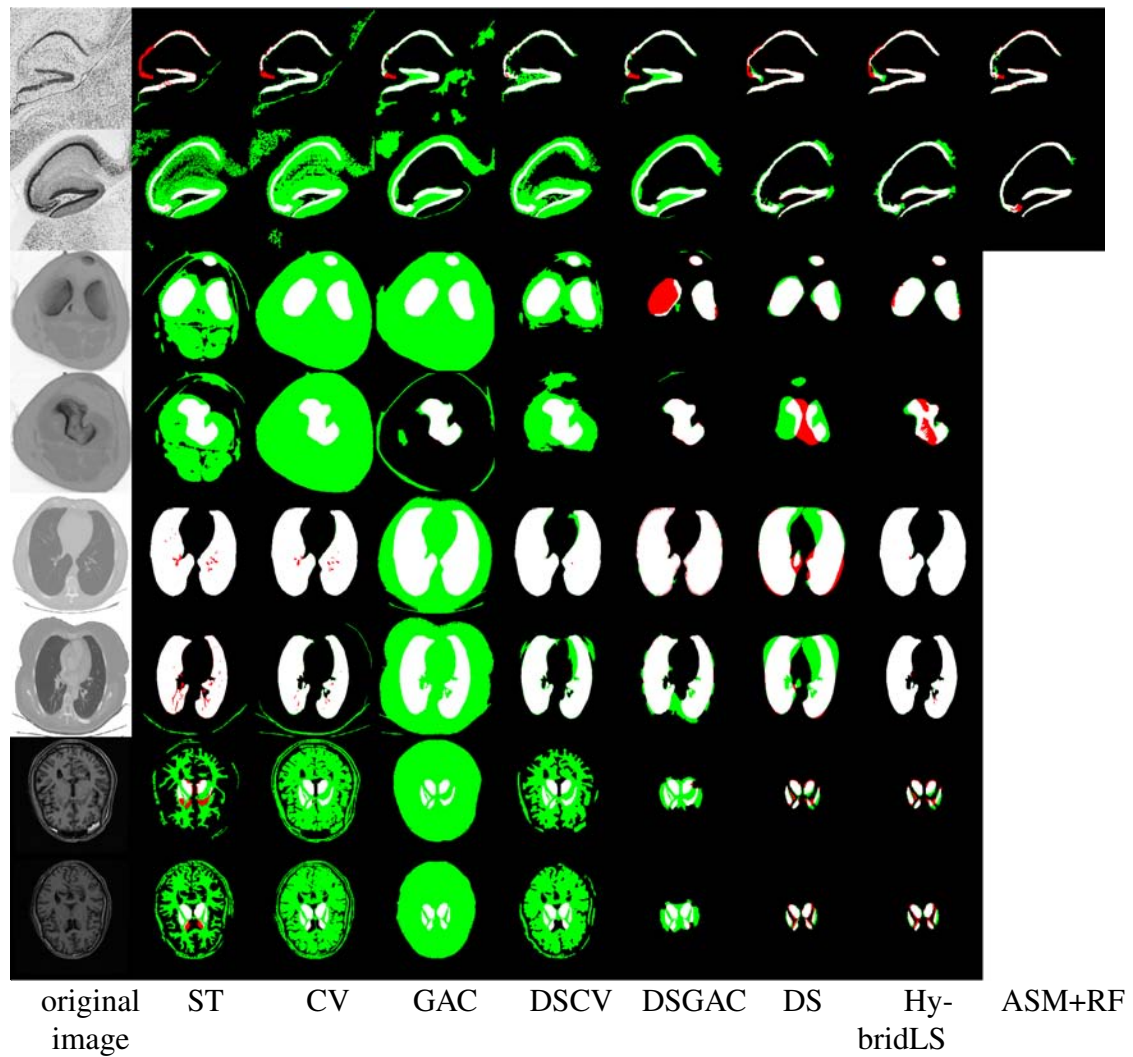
Some visual examples of the results obtained. Two images per image modality and per structure to segment have been selected: the first two rows correspond to ISH, the next two rows to CT-Knee, and the last four to CT-Lungs and MRI. White represents true positives, red false negatives, and green false positives.
